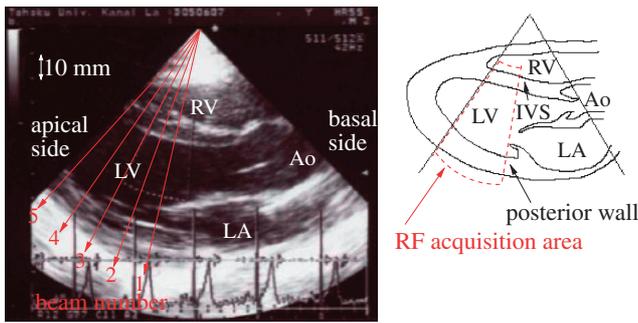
Cross-sectional image of the left ventricle in the long-axis view obtained by conventional echocardiography for a healthy 22-year-old male. The red arrows show the direction of the five ultrasonic beams used for the estimation of strain rate in the IVS and posterior wall.
